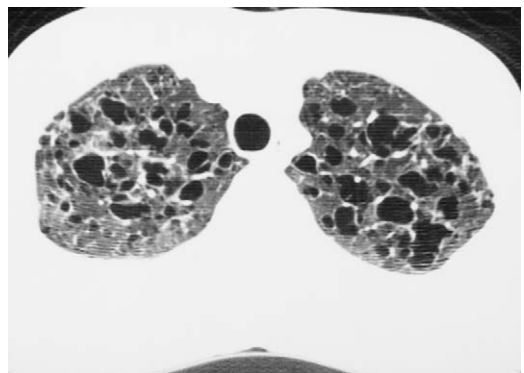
LCH. CT shows multiple cysts of variable sizes in both upper lungs, a late and irreversible finding.
